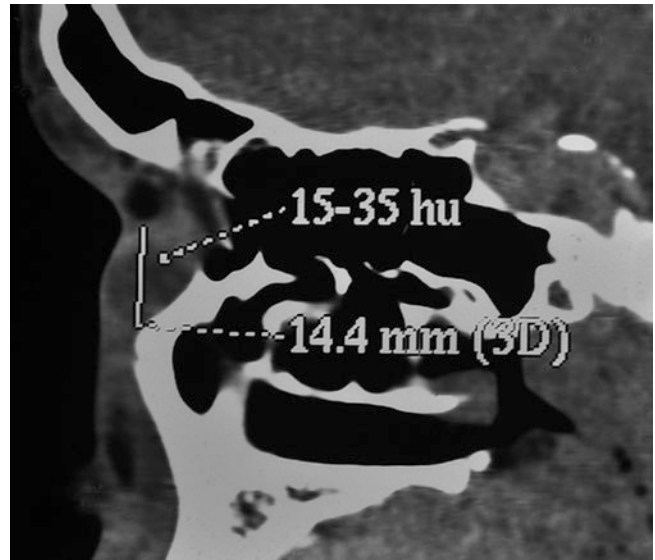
CT Scan, sagittal reconstruction of the patient in Fig. 2.17, showing the lacrimal sac diverticula
